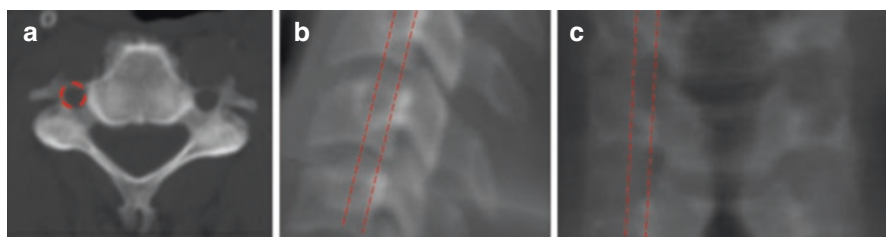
Course of the vertebral artery in the foramen transversarium: the course of the vertebral artery in the foramen transversarium, from C6 to C3 (in some individual also at C7), is shown on cross-sectional axial (a), LL (b), and AP (c) fluoroscopic images with *red dashed lines*. The course at C2–C1 is not shown here, but typically better depicted on cross-sectional CT images
